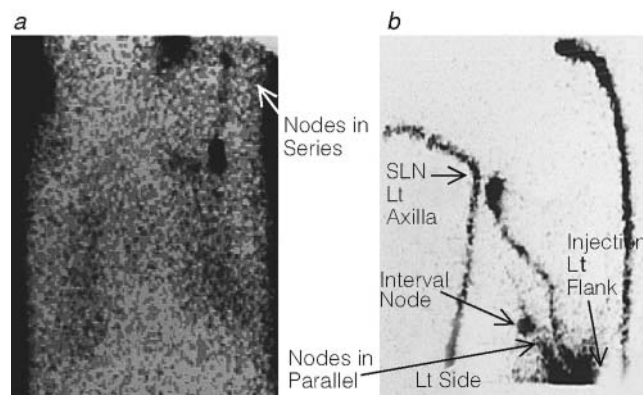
Lymphatic mapping and sentinel lymph node (SLN) biopsy for melanoma. In-transit nodal areas are identified in 5% of melanoma patients; this is the reason why preoperative lymphoscintigraphy is performed for primary sites on either the upper or the lower extremity. In a patient with a melanoma on the left hand (a), the injection site and the left arm are raised above the head, and cutaneous lymphatic flow into an epitrochlear node can be seen. This in-transit node then emits a lymphatic vessel flowing to the left axilla. By definition, the SLN is the first node in the chain that receives primary lymphatic flow. The epitrochlear node and any axillary nodes are nodes in series. Hence, the epitrochlear node is the SLN and thus is the only node that must be harvested. In a patient with a primary melanoma on the left flank (b), there are two separate afferent lymphatics, one leading to an SLN in the left axilla and the other leading to an in-transit node on the left flank. These are nodes in parallel in that they both receive primary lymphatic flow from the skin site. Hence, the two nodes are equally at risk for metastatic disease, and both are considered sentinel nodes and must be harvested.
